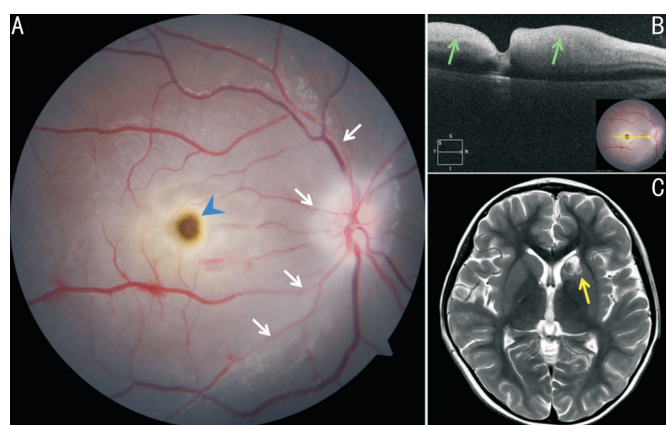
FP (A), OCT (B) and cranial MRI (C) results after the deterioration of the patient's eyesight A: The white arrow pointed to the extremely narrowed retinal arteries diffuse retinal whitening, and the blue one pointed to cherry red spot in the macular of FP image; B: The green arrow pointed to retinal edema near the optic disk in OCT; C: The yellow arrow pointed to the infarction area within the brain parenchyma. FP: Fundus photography; OCT: Optical coherence tomography; MRI: Magnetic resonance imaging.
